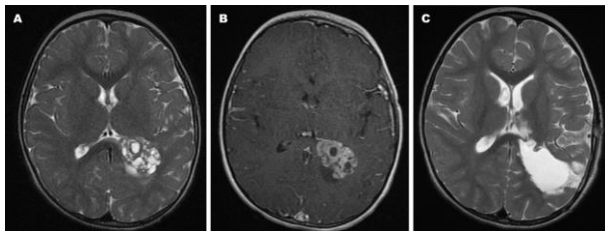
Baseline magnetic resonance of brain in axial T2-weighted (A) and contrast-enhanced (B), and postoperative T2-weighted imaging.
